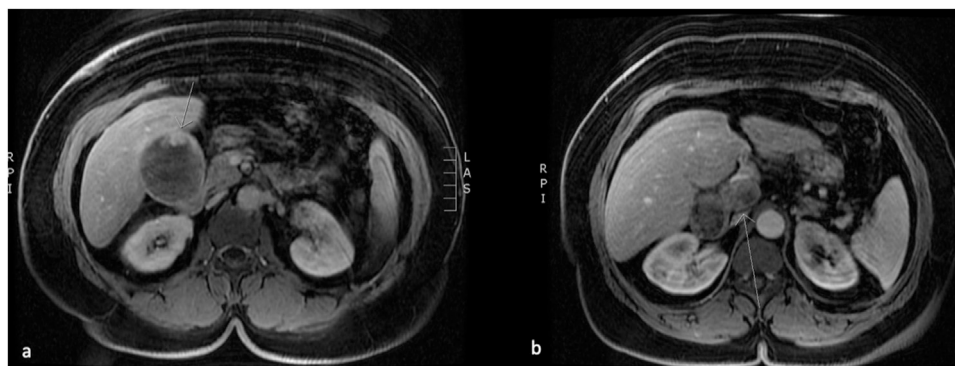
CT Abdomen on axial view showing distended gallbladder with gallstones and asymmetric wall thickness with fat stranding, portacaval lymph node close to the pancreatic head.
